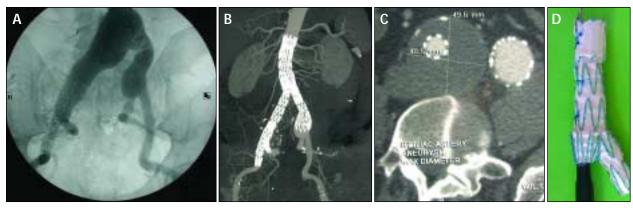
Angiography shows a large AAA along with a right common iliac artery aneurysm involving the hypogastric artery (A). A branched endograft was used to exclude the aneurysms while maintaining the hypogastric circulation (B). Follow-up CT scan shows complete exclusion of the right common iliac aneurysm with no endoleak (C). A branched endograft with a large flare for the contralateral limb was used in this case (D).
